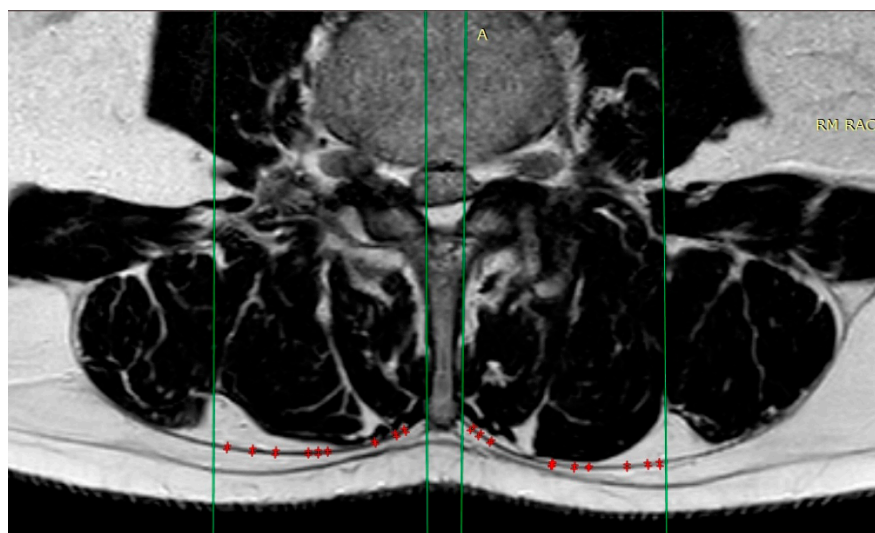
MRI assessment of TLF thickness in the axial plane at the L3 level. The green reference lines define the region of interest: one lines drawn parallel to the spinous process (medial boundaries) and a second line at each side drawn at the longissimus–iliocostalis interface (lateral boundaries). The red markers indicate individual caliper measurements of TLF thickness with three measurements per third.
